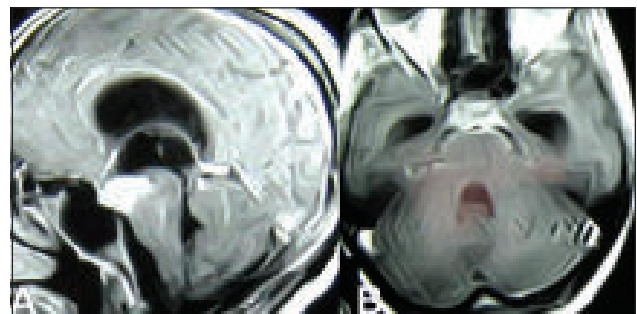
MRI of brain A-sagittal view, B-axial view showing tuberculus lesion in the floor of third ventricle.
